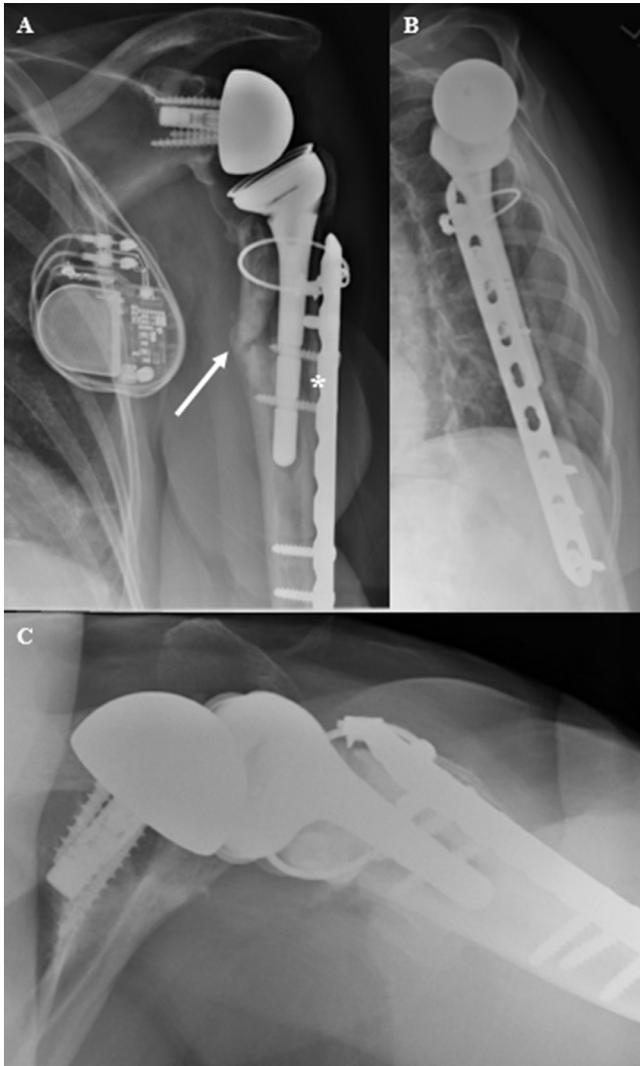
Postoperative radiographs of an 85-year-old female who underwent reverse total shoulder prosthesis with plate osteosynthesis for failed intramedullary nail fixation. (A) Anteroposterior and (B) lateral views.
